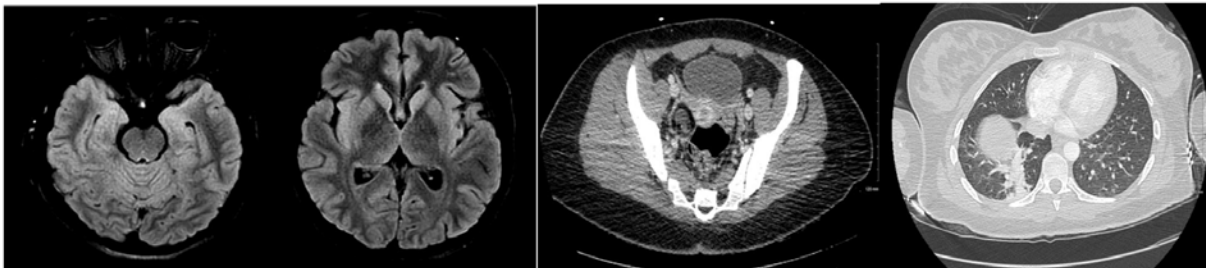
shows symmetrically increased FLAIR signal intensity in bilateral medial temporal lobes. Image 2 demonstrates symmetrically increased FLAIR signal intensity in bilateral insula, medial frontal lobes and caudate heads along with bilateral frontal subcortical white matter FLAIR hyperintense foci. Image 3 demonstrates right adnexal dermoid. Image 4 shows right lower lobe consolidation.
